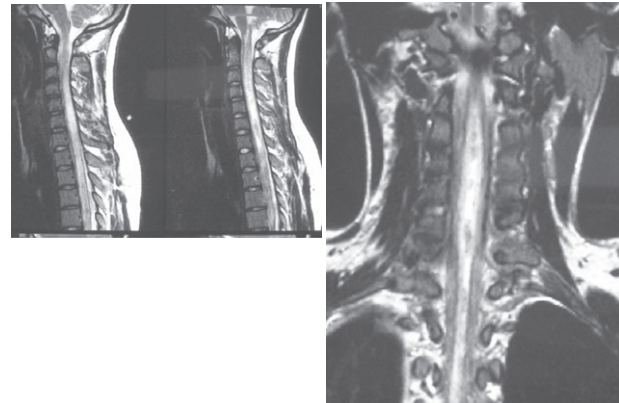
a & b: MRI (T2-weighted sagittal and coronal) showing cervical syringomyelia
